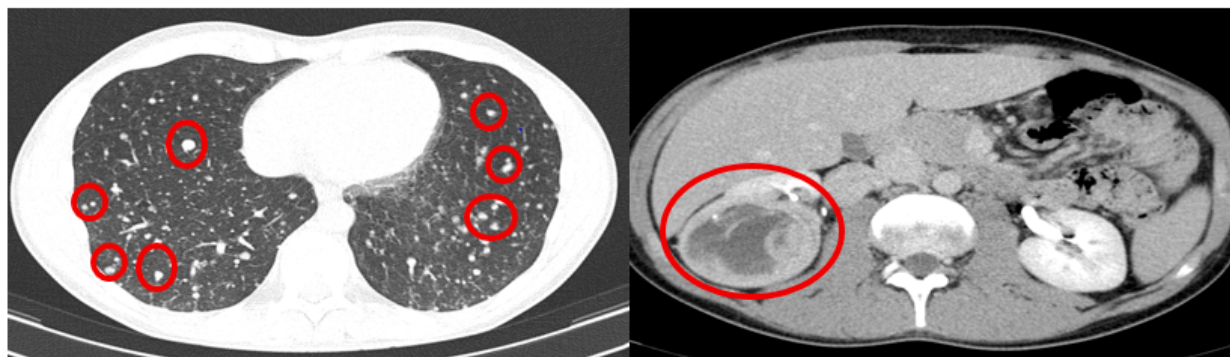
Initial CT scan in December 2023.
